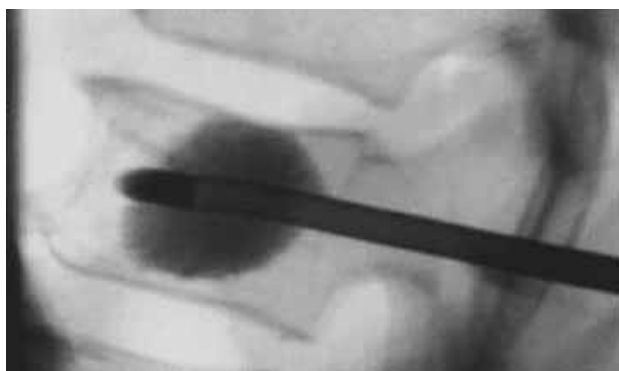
X-ray of lumbar vertebral in lateral projection taken after application of cement showing good position.
